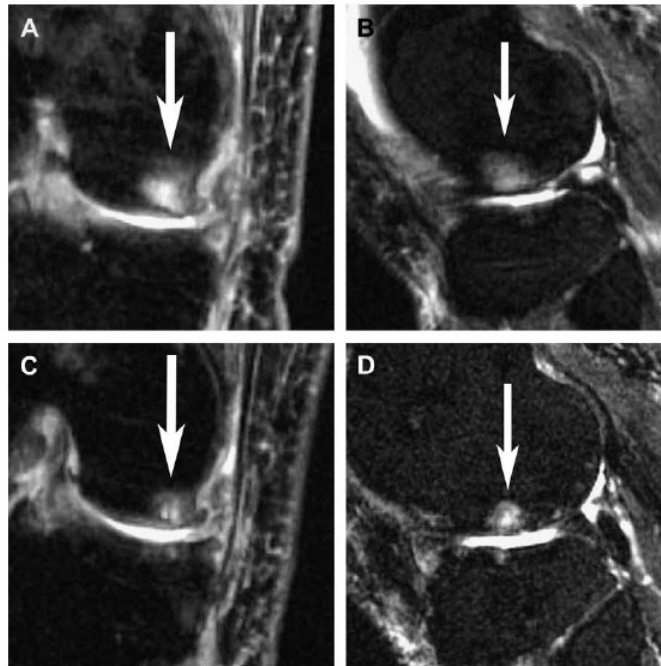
Baseline and Follow-up MRIs of a 53-year-old male patient with SBC development. (A) A baseline T2-weighted coronal view of a subchondral bone region with a bone marrow edema-like signal. (B) A baseline T2-weighted sagittal view of a subchondral bone region with a bone marrow edema-like signal. (C) A T2-weighted coronal view MRI at 12.5 months follow-up showing development of a SBC. (D) A T2-weighted sagittal view MRI at 12.5 months follow-up showing development of a SBC. Reproduced with permission from Carrino, JA et al., *MRI of Bone Marrow Edema-Like Signal in the Pathogenesis of Subchondral Cysts*. *Osteoarthritis and Cartilage*, 2006. 14(10): p. 1081-1085).
